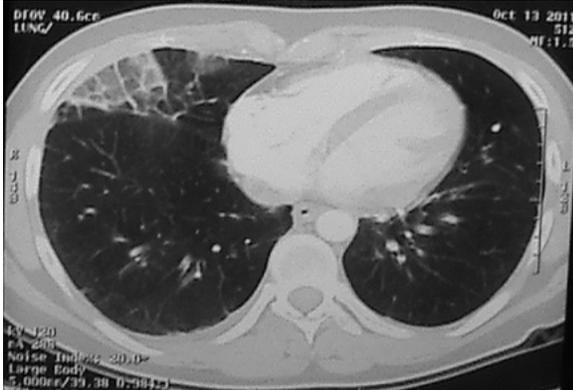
CT chest (lung window) showing peripheral wedge shaped opacity in right middle lobe suggestive of infarction
